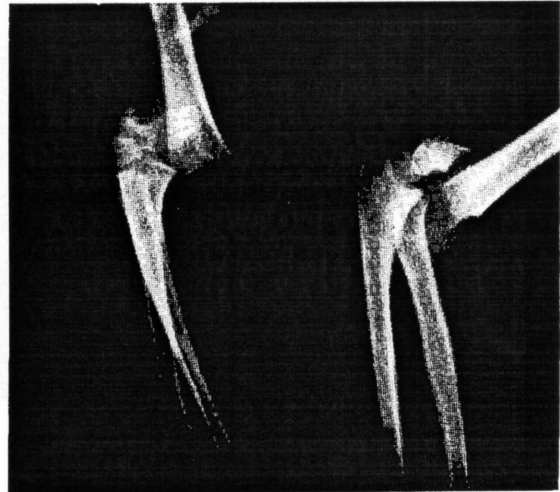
Roentgenogram in this instance shows moderate displacement.
